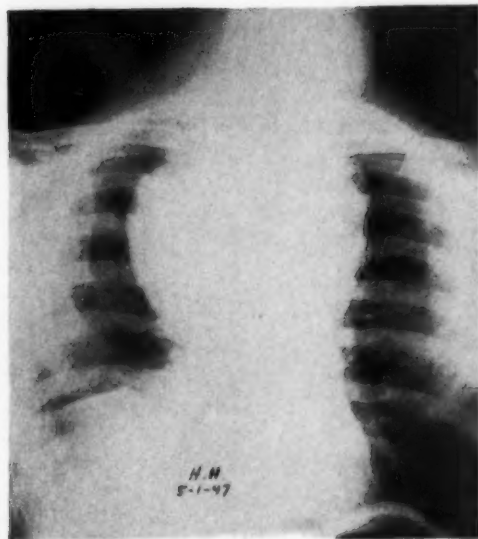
Case 2. Roentgenogram showing large mediastinal mass, elevation of the right diaphragm, soft-tissue mass in the right neck. No bone destruction is seen.
